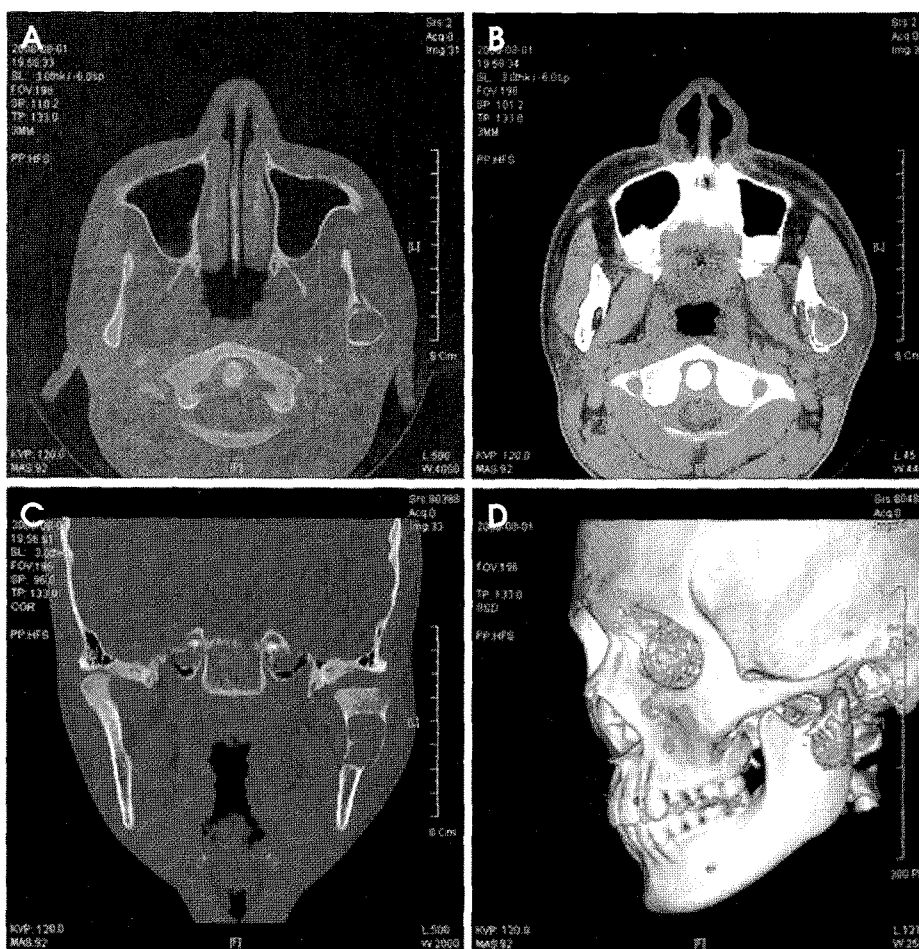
Axial (A, B) and Coronal (C) CT scans show cortical expansion especially lateral side and thinning. Three-dimensional (D) CT shows fracture of subcondylar neck and displacement of bony fragment.
